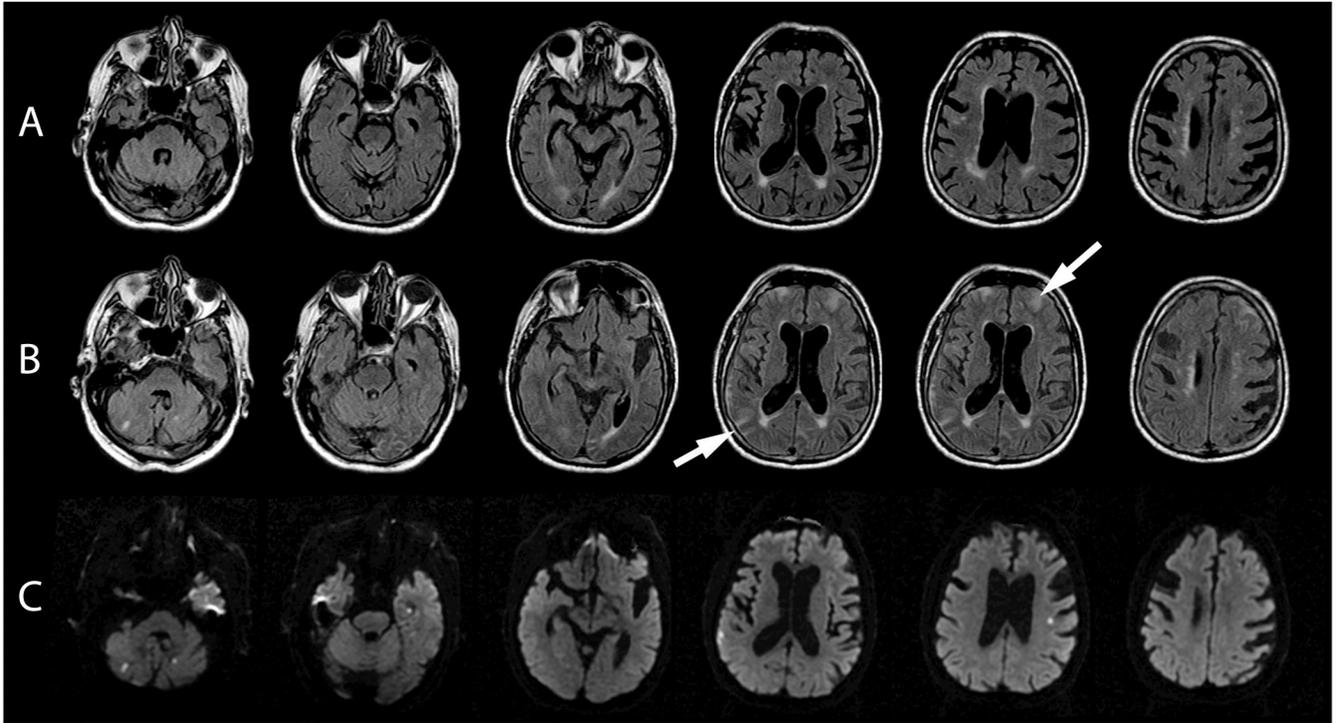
Sulcal HARM 86-year old man who underwent CABG. A: Baseline FLAIR done before surgery. B. Post-gadolinium FLAIR. Gadolinium was administered 23 hours after surgery and the 1.5T MRI was obtained 27 hours later. Post-gadolinium FLAIR shows bright enhancement in the right frontal and left parietal subarachnoid space (severe sulcal HARM, arrows). C. Postoperative DWI. The patient had six DWI lesions. .
